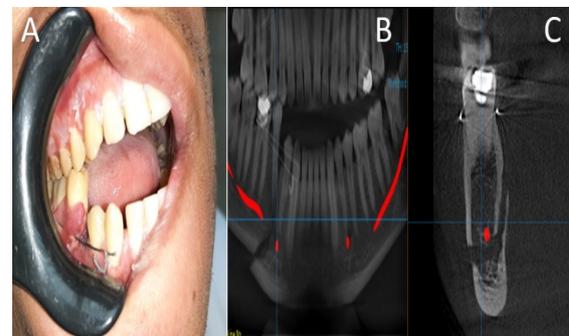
(A) clinical photograph showing preoperative occlusion (B) preoperative panoramic view (C) preoperative axial cut from CBCT showing the fracture line.
